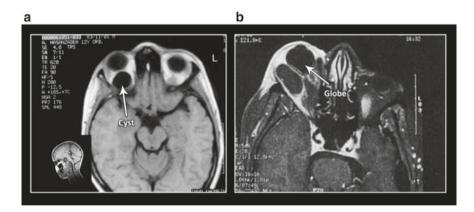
a A T1W MRI in axial view. The vitreous fluid is typically dark, whereas the fat appears bright. b A T2W MRI in axial view. The vitreous appears bright, whereas the fat is intermediate. Another T2W image that fat appears in high signal intensity
